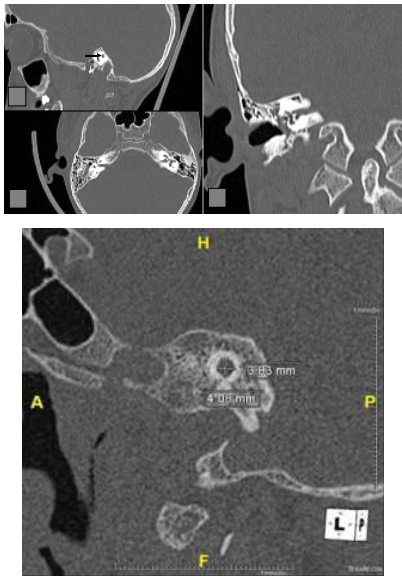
HRCT Temporal bone, sagittal section, showing the method of measuring the diameters of internal auditory canal.
